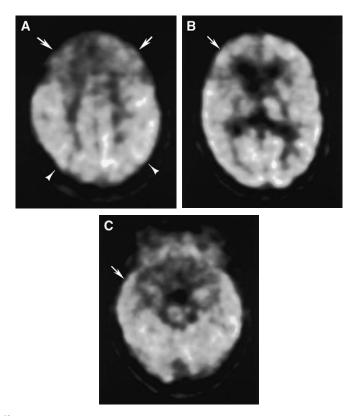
[<sup>18</sup> F]-FDG-PET image in a 70-year-old woman with frontotemporal dementia. (*A*) Normal metabolic activity is seen within both parietal lobes (*arrowheads*). (*A*, *B*) FDG-PET shows prominent diminished FDG uptake in both frontal lobes, more marked on the right (*arrows*). (*C*) Diminished FDG uptake is seen to a lesser degree within the temporal lobes and is more marked on the right (*arrow*).
